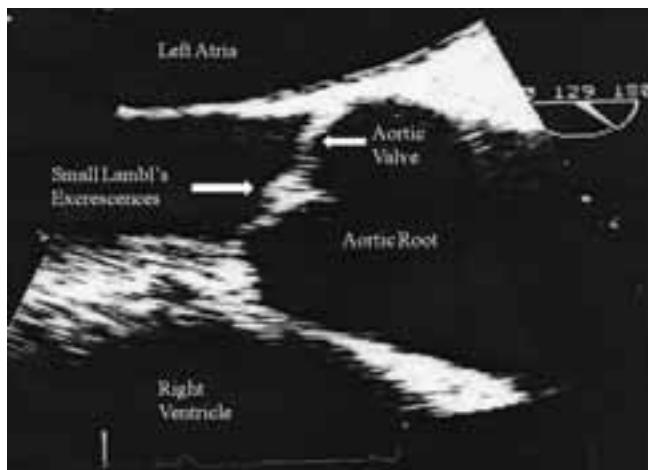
Transesophageal echocardiogram showing the small filiform process (Lambl's excrescences) on the aortic valve ventricular surface.
